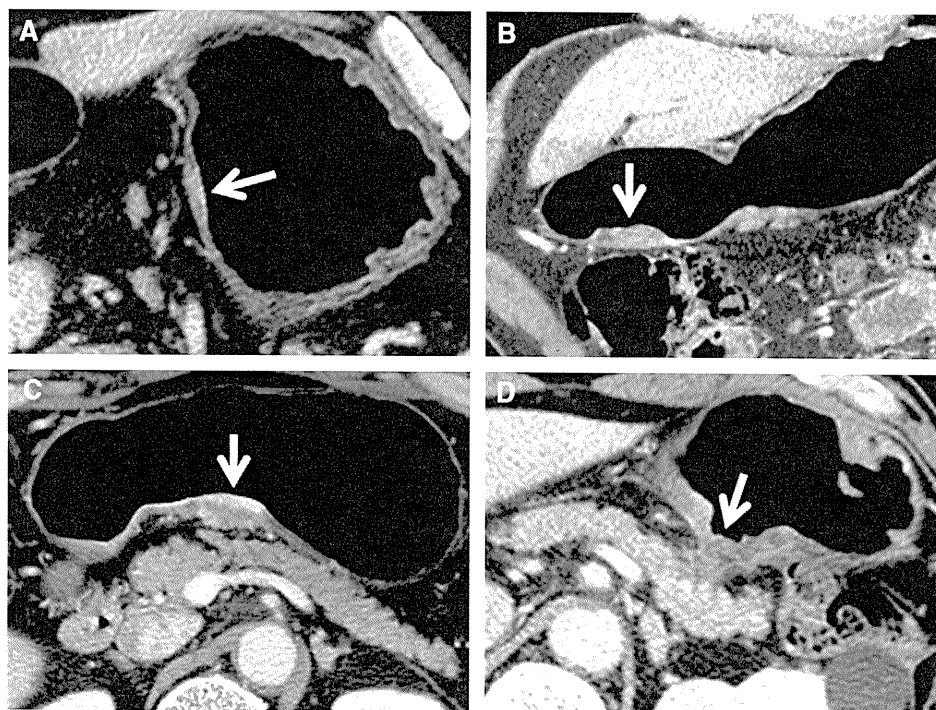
The representative CT images of each T1, T2-3, T4a, and T4b tumors. (A) T1 detectable tumor; transverse CT showed enhancement with focal thickening (*arrow*) in inner and middle layers, but the outer layer was intact. (B) T2-3 tumor; irregularly enhancing wall thickening (*arrow*) in entire stomach wall without perigastric fatty infiltration. (C) T4a tumor; irregularly enhancing wall thickening (*arrow*) with irregular outer border. (D) T4b tumor; extension of tumors to adjacent pancreas.
